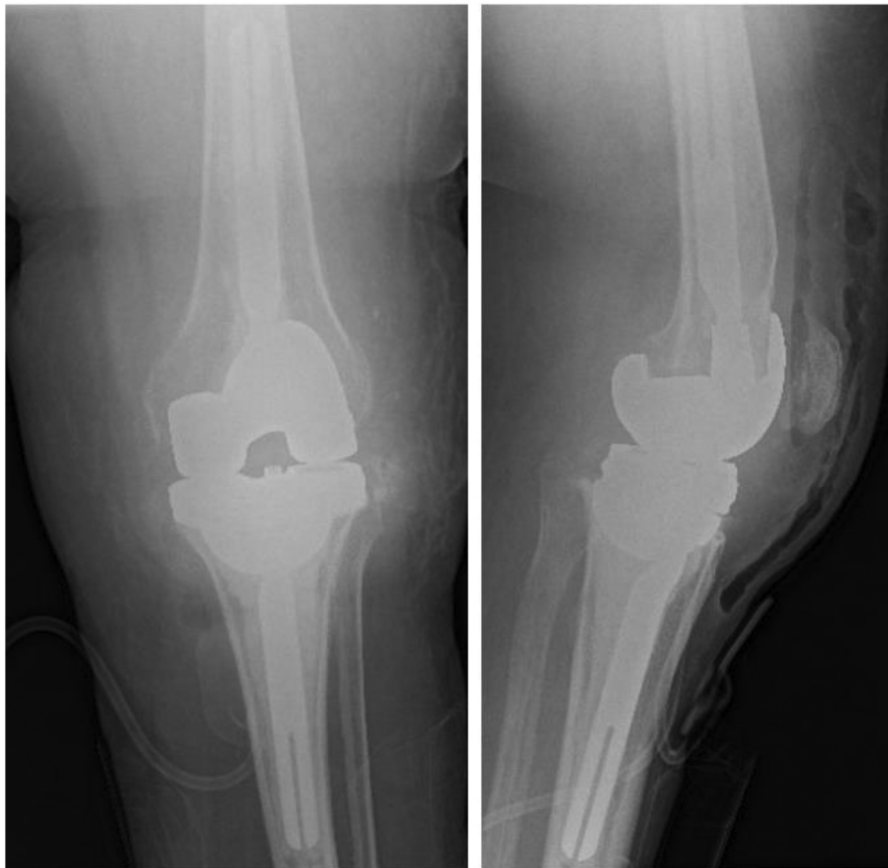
Anteroposterior (left) and lateral (right) radiographs of the patient's left knee postoperatively. The tibial construct includes a size-54 trabecular metal revision acetabular shell, 5-mm augments, and a tibial base plate.
